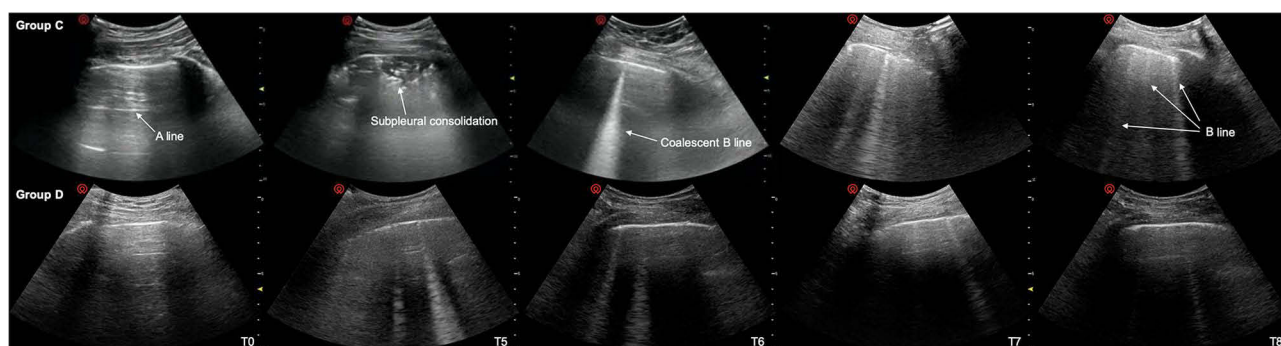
Lung ultrasound images in the left inferoposterior quadrant of one representative patient from each group at each time point.
